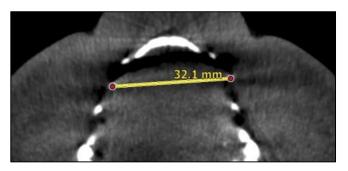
"IPM" parameter: CBCT image in the axial plane.
